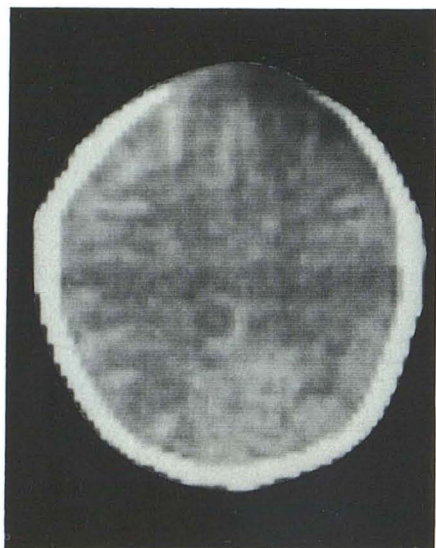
31-day-old infant. Unenhanced CT scan at 14 days after presentation. Linear areas of increased density in cortical region, somewhat more obvious in right hemisphere than on left.
